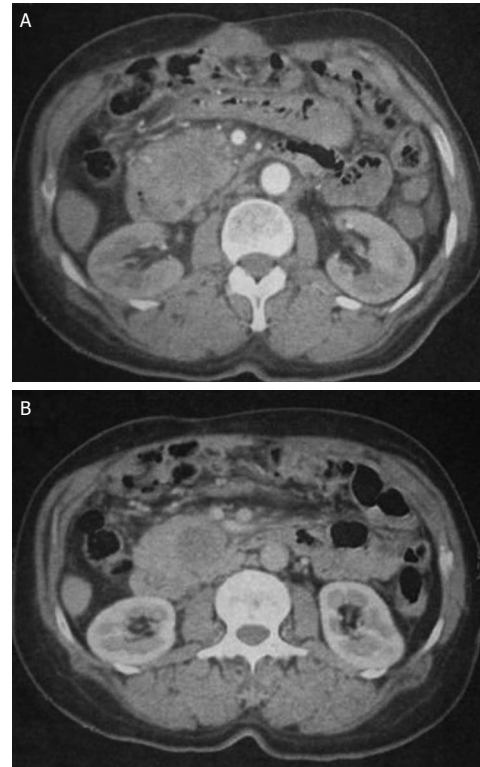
Abdominal CT: low-density mass in the pancreatic head. A: Arterial phase; B: Portal phase. CT: Computed tomography.
